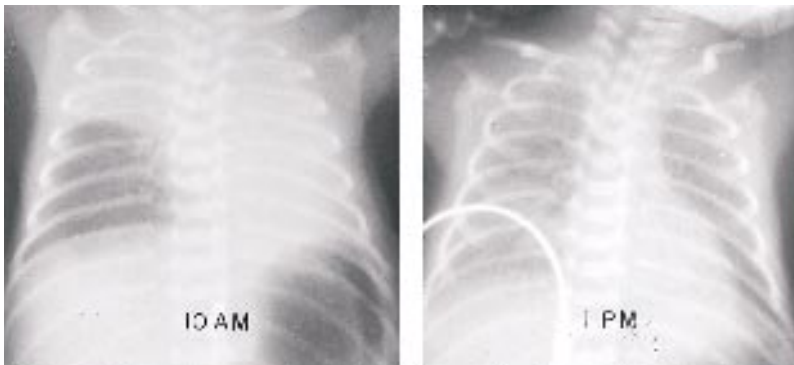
Serial chest radiographs of an infant with left lung and right upper lobe opacification as the result of right mainstem bronchus intubation (left). After repositioning the endotracheal tube there was rapid resolution of the atelectasis (right).
